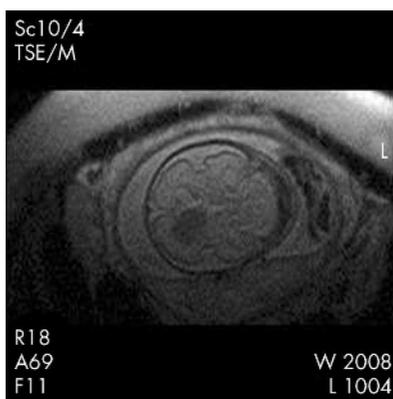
Fetal MRI scan. Axial T2 weighted image at 24 weeks, showing a low signal mass in the body of the left lateral ventricle.
